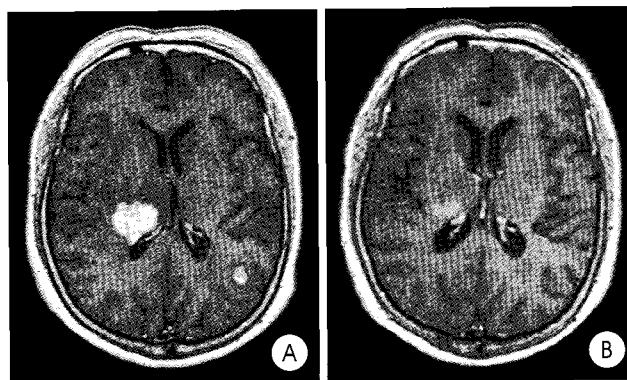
Case No 3. Initial gadolinium(Gd) enhanced T1 weighted axial magnetic resonance(MR) image (A) shows that well-enhanced two mass located in right thalamus and left occipital gyrus. One month After radiosurgery, T1 weighted Gd enhanced axial MR image (B) reveals that the mass size is significantly reduced.
